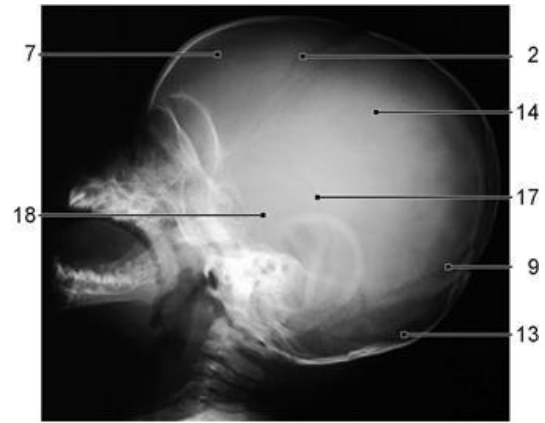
Lateral radiograph of the skull, age 6 months.
